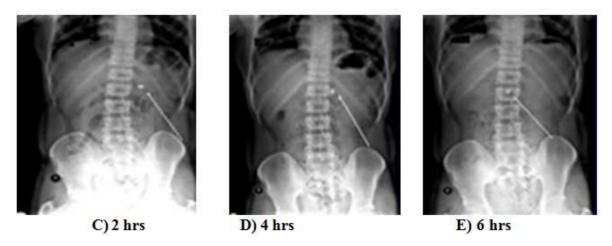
Radiographic images showing the presence of a BaSO₄ loaded bilayer floating tablet (F7) in the stomach at a different time periods
